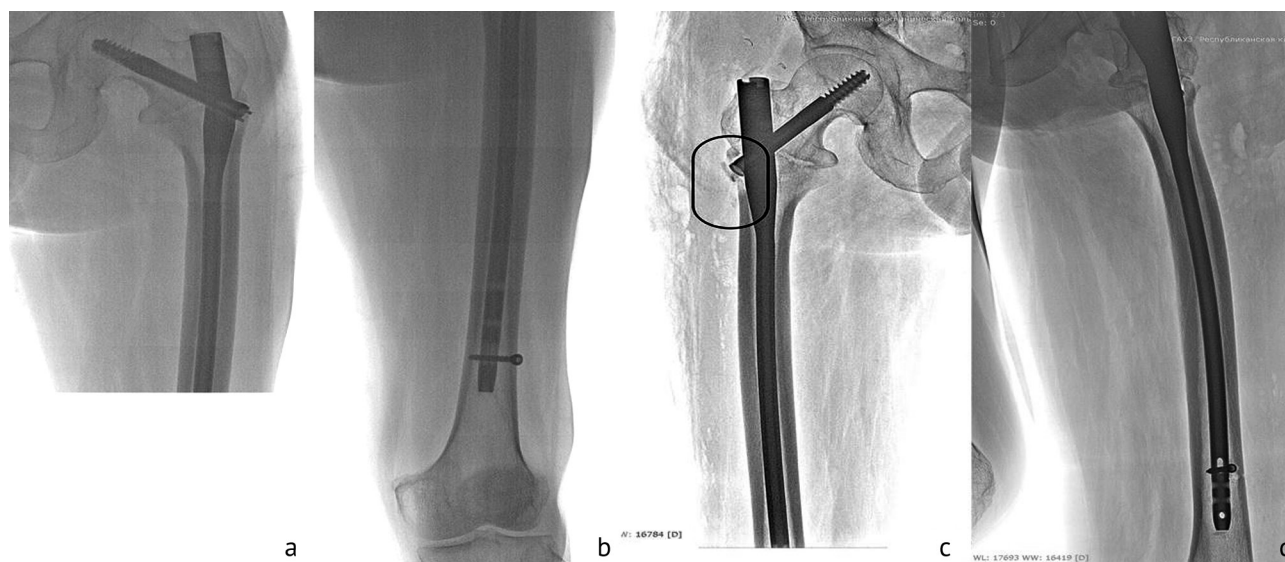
Radiographs of the patient's hip joint showing (a, b) failed union of intertrochanteric fracture and deformed nail on preoperative AP view; (c) cephalomedullary reosteosynthesis of the intertrochanteric fracture, the lateral corticotomy of the femur under the entry point of the dynamic screw circled with an oval on the AP view; (d) cephalomedullary reosteosynthesis of the non-united intertrochanteric fracture of the femur on the axial view
